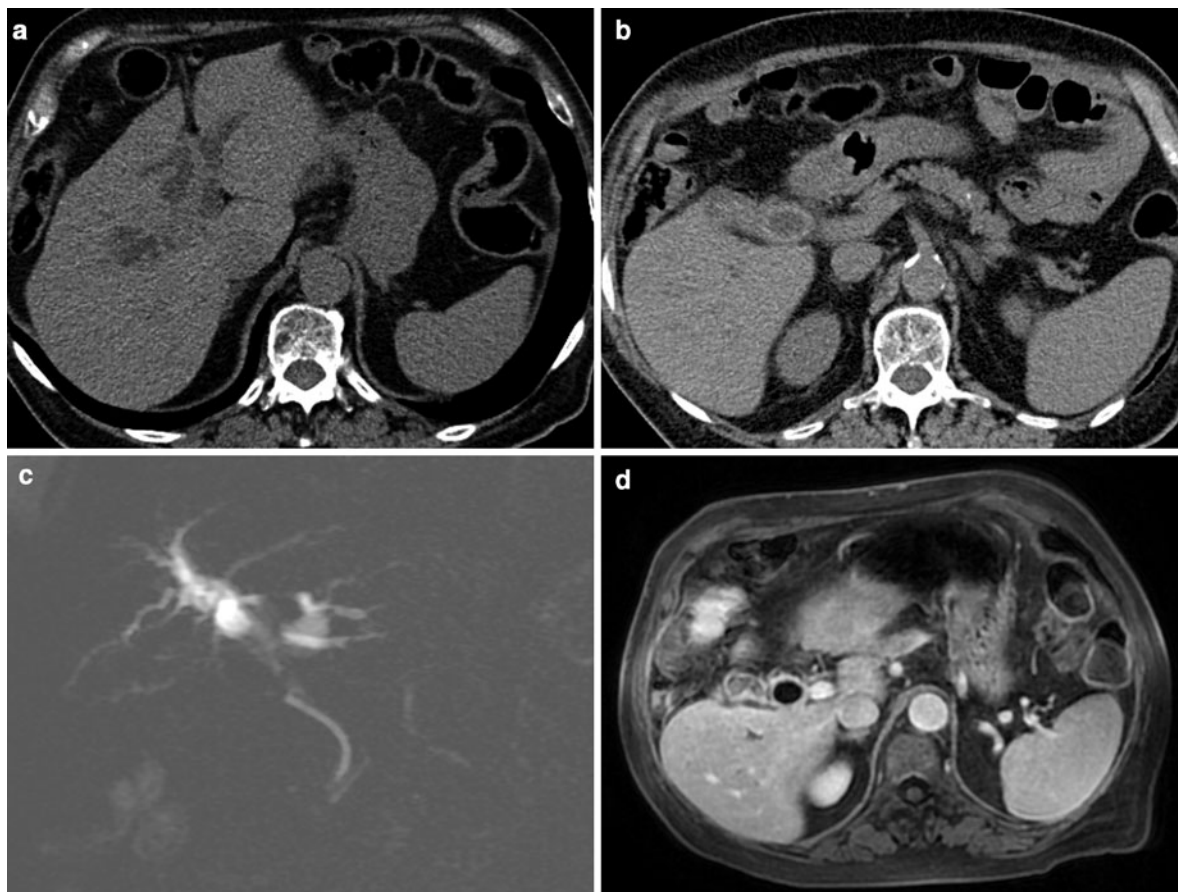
Mirizzi syndrome. A 72-year-old man with progressive jaundice. US shows dilatation of intrahepatic bile ducts, but not of the lower common bile duct. The gallbladder area is difficult to analyze. Plain CT (a, b) and MRI (c, d) were performed. On plain CT, intrahepatic dilation of the bile duct is seen (a). On a lower slice (b), a stone is detected, appearing as hypoattenuating in the center and slightly hyperattenuating at the periphery. In the gallbladder fossa, the stone is seen in the gallbladder neck area, and the gallbladder seems to be
